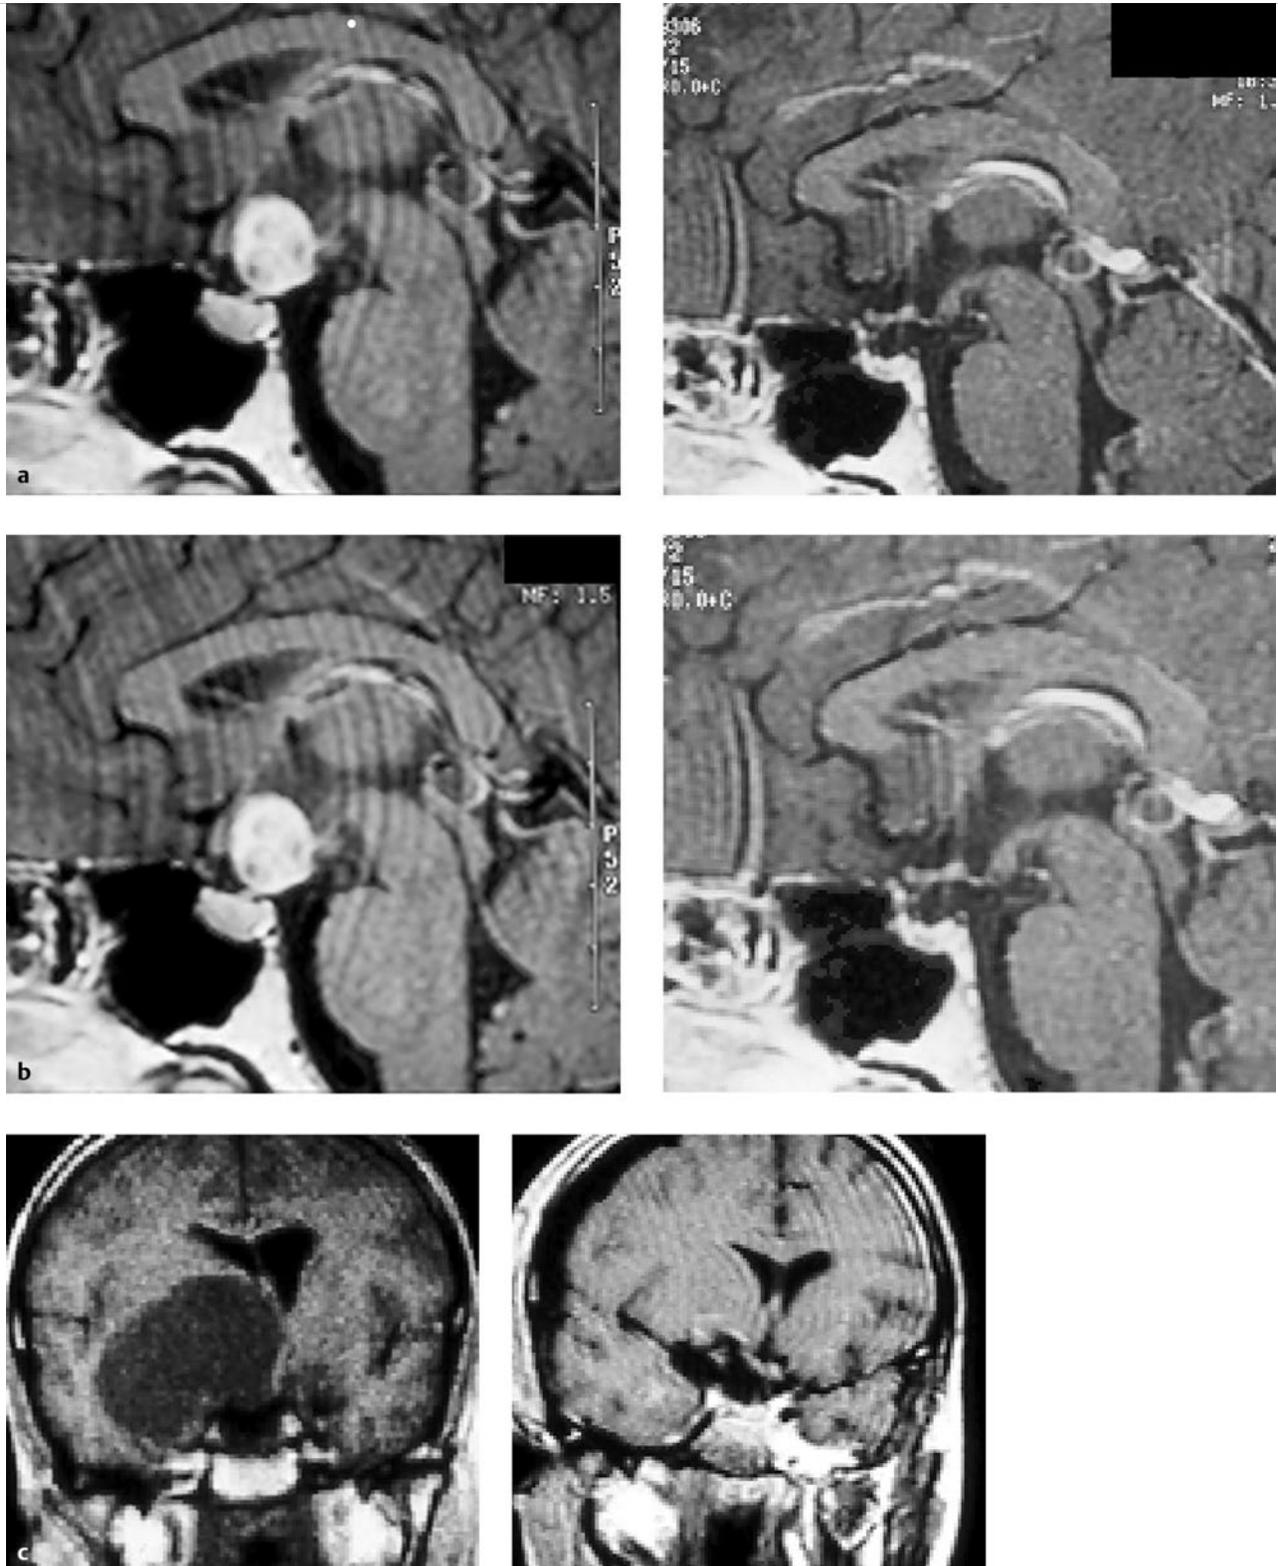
(a) Pre- and postoperative magnetic resonance (MR) images of a small (2 cm) craniopharyngioma. (b) Pre- and postoperative MR images of a medium (4 cm) craniopharyngioma. (c) Pre- and postoperative MR images of a large (5 cm) craniopharyngioma. (continued)
